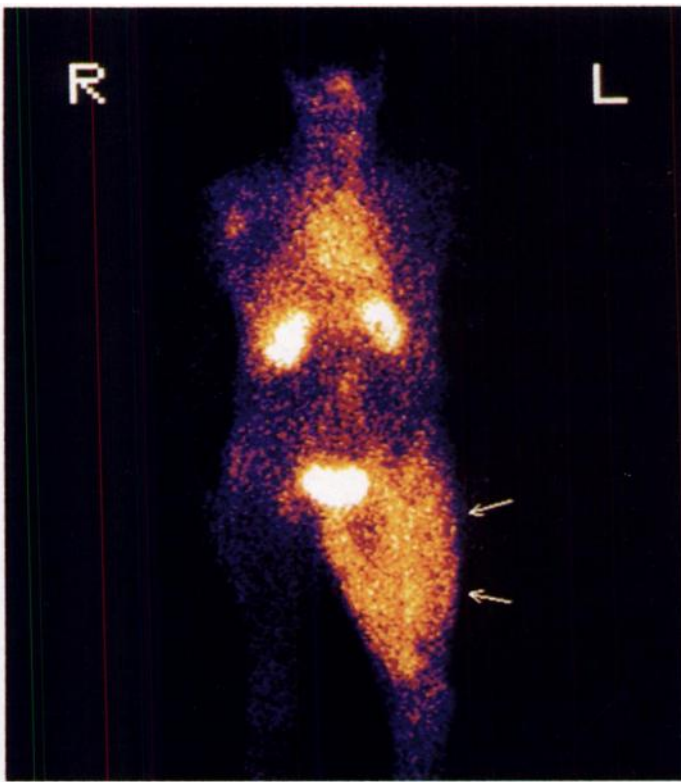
Whole-body scan of Patient 8 obtained 10 min postinjection revealed widespread uptake of the tracer in the left thigh (arrows), without involvement of the aortobifemoral prosthesis. CT confirmed multiple abscesses in the muscles of the thigh and the patient fared well after drainage of abscesses and antibiotic therapy.
